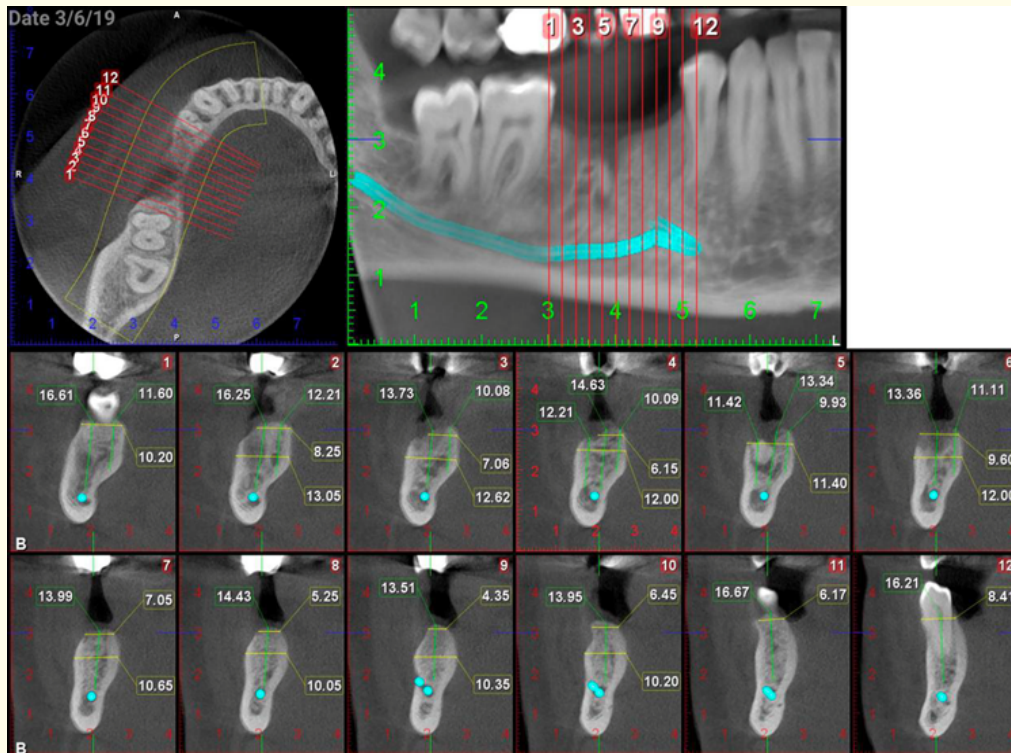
CBCT scan of the right mandibular hemiarch.
